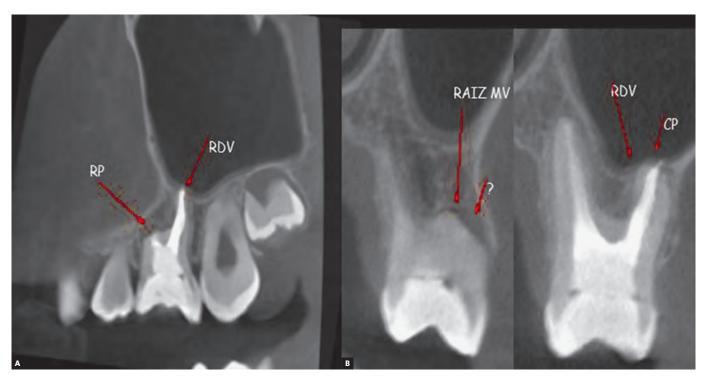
Final CBCT scans show satisfactory healing and bone repair at A) 6-month and B) year follow-up.
